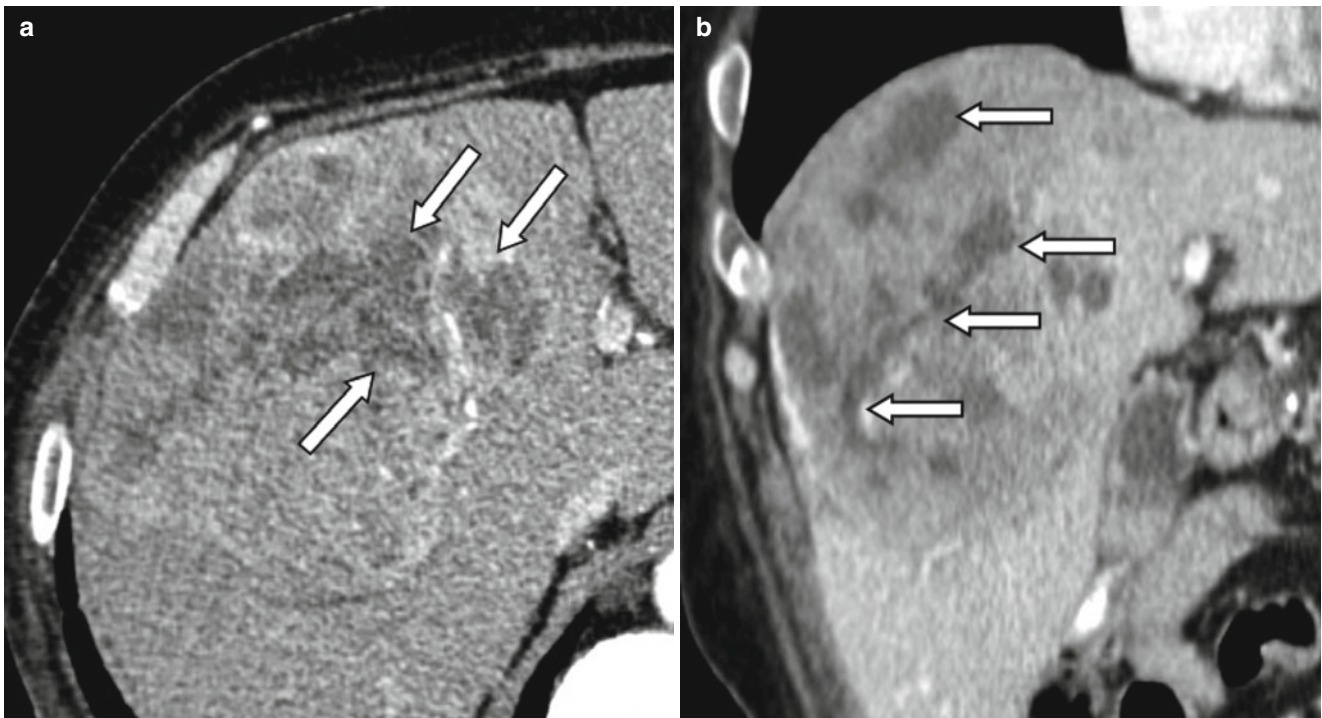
Contrast-enhanced CT of a 67-year-old male patient with HCC treated with radioembolization. (a) The percentage of necrosis after treatment on the axial slices can be measured differently depending on which level it was measured. (b) Coronal view shows the heterogeneous distribution of necrosis within the tumor. *Arrows* indicate necrotic portion of the tumor on the axial (a) and coronal (b) planes
